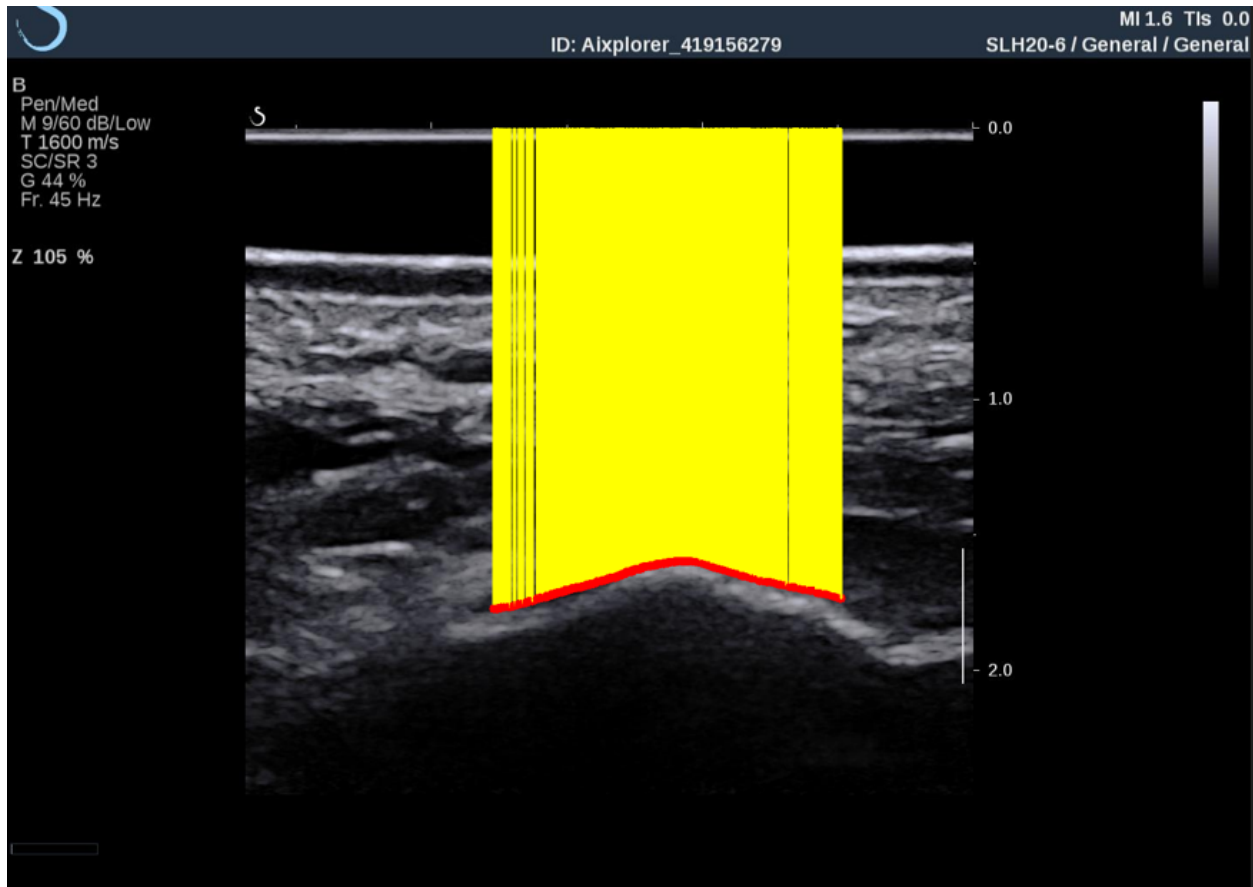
Vertical distances (yellow) overlaid over an ultrasound image of the heel with the calcaneus (red) and probe (blue) labeled.
